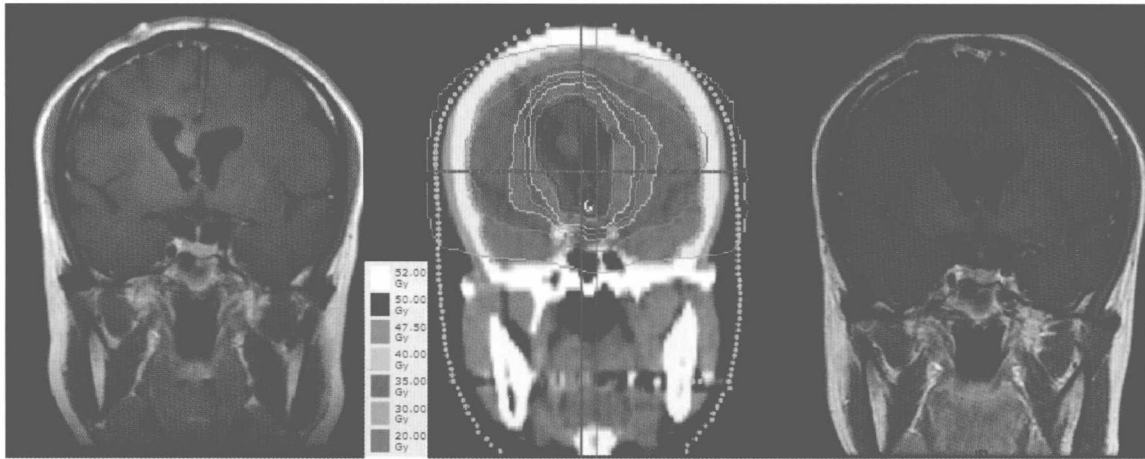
Pre-radiation coronal T1-enhanced MRI of a 38-year-old woman with recurrent central neurocytoma (left panel) treated with image-guided conformal radiotherapy (middle panel) and with a near total radiographic response to treatment and subsequently stable disease 5 years post radiation (right panel).
